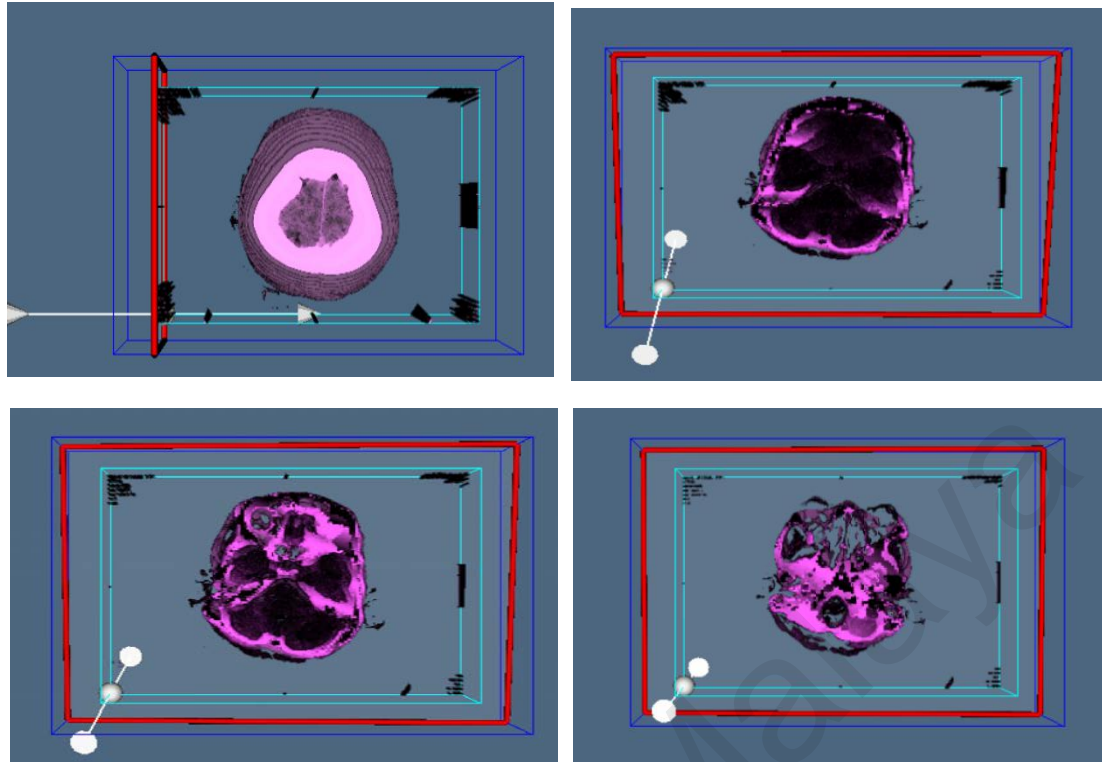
3 Volumetric Rendering Results of CT Brain Image. (25 2D image with 1012x706)
